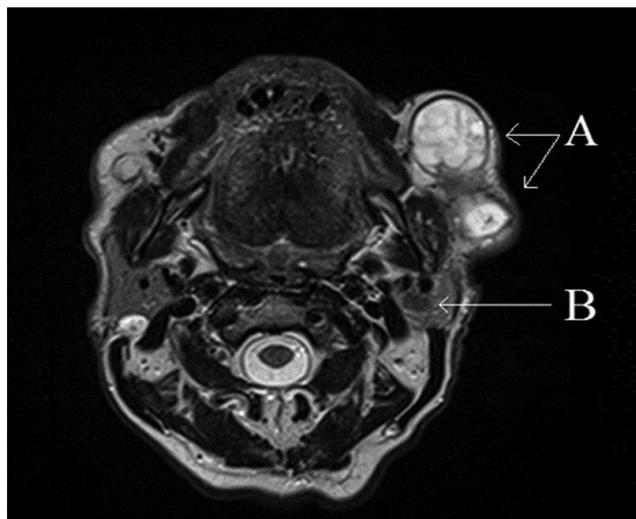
MRI of the facial part of the cranium. The arrow indicates the extensive tumour of the accessory parotid gland (A) and within the superficial lobe of the parotid (B).
